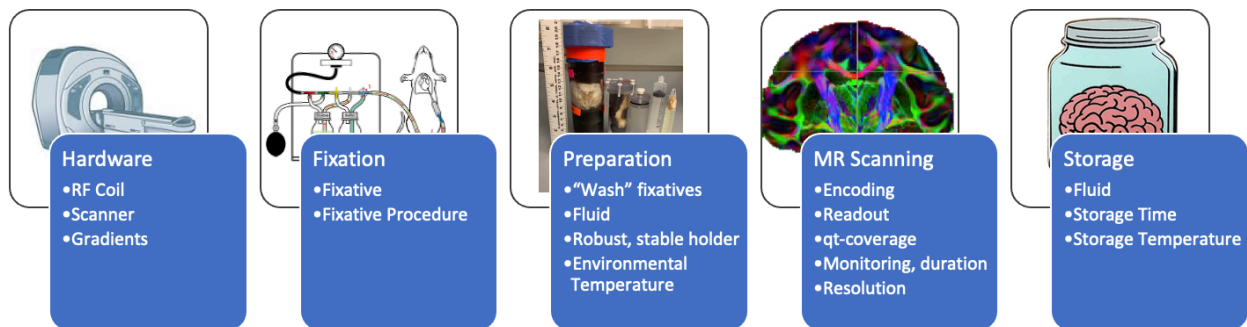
For high-quality *ex vivo* diffusion MRI, decisions regarding hardware, fixation, preparation, MR scanning, and tissue storage must be carefully considered. Hardware: utilize the smallest coil that fits the sample under investigation, to maximize SNR. Fixation: for *ex vivo* tissue to be a good model of *in vivo*, the post-mortem interval to fixation must be as short as possible. Preparation: washing out fixative and soaking tissue in a solution of Gadolinium-based contrast agent decreases primarily water-protons T_1 which in turn allows for a favorable trade-off between SNR maximization and TR reduction (i.e., reduced acquisition time), while a robust physical setup eliminates motion during scanning. MR Scanning: A multi-shot 3D diffusion-weighted spin echo EPI or multi-shot 3D diffusion-weighted RARE/FSE sequence. While not typically used *in vivo* due to motion sensitivity and long scan time, these sequences combine advantages of high SNR, minimal distortion, and reasonable scan time *ex vivo*. Storage: fixed tissue can be stored for many months to several years if stored in fixative or phosphate buffered solution (often with 1% PFA) at 5°C.
